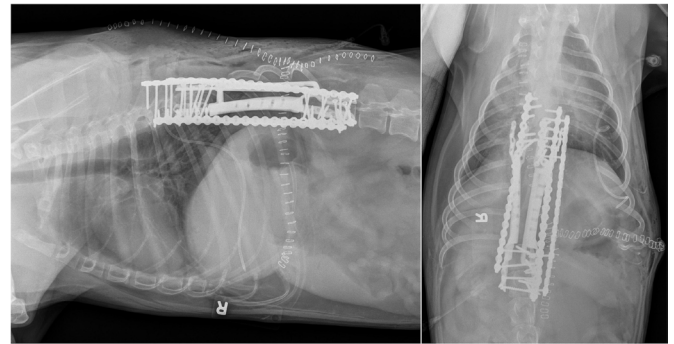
Immediate postoperative lateral (A) and ventrodorsal (B) radiographs showing multisegment en bloc vertebrectomy of T9–T12 and reconstruction with a patient-specific prosthesis and three 2.7 mm SOP plates. SOP: string-of-pearls.
